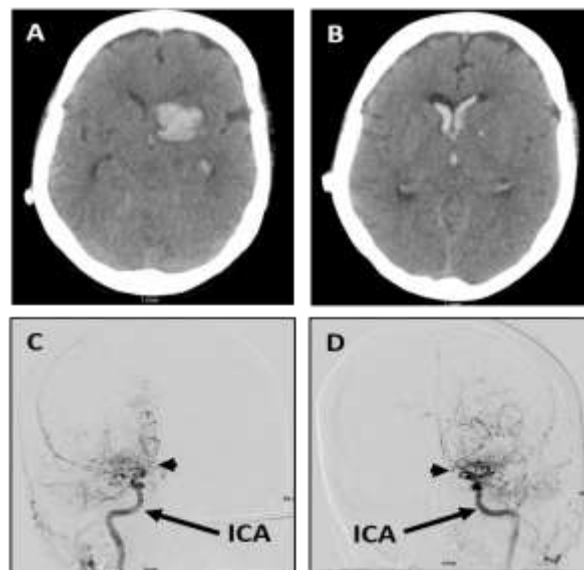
Non-contrast CT scan shows left caudate intracerebral hemorrhage (A) and intraventricular hemorrhage (B). Right (C) and left (D) AP views on digital subtraction angiography demonstrate bilateral moyamoya with occlusion of the supraclinoid internal carotid arteries (ICA; arrow) and robust lenticulostriate collateral formation (arrowhead).
